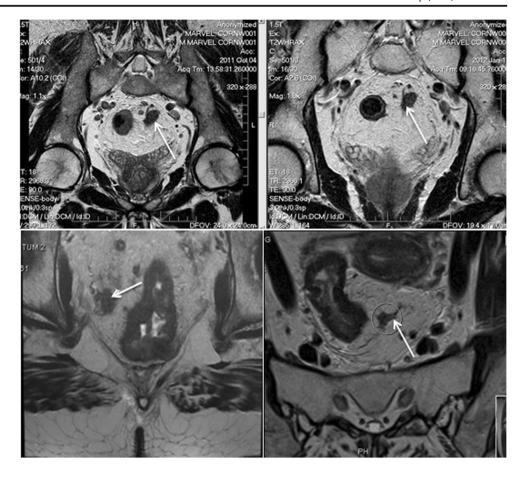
MRI scans showing the appearance of tumour deposits (arrows)
